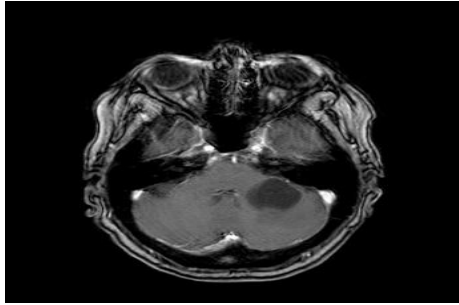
Initial axial contrasted MRI
